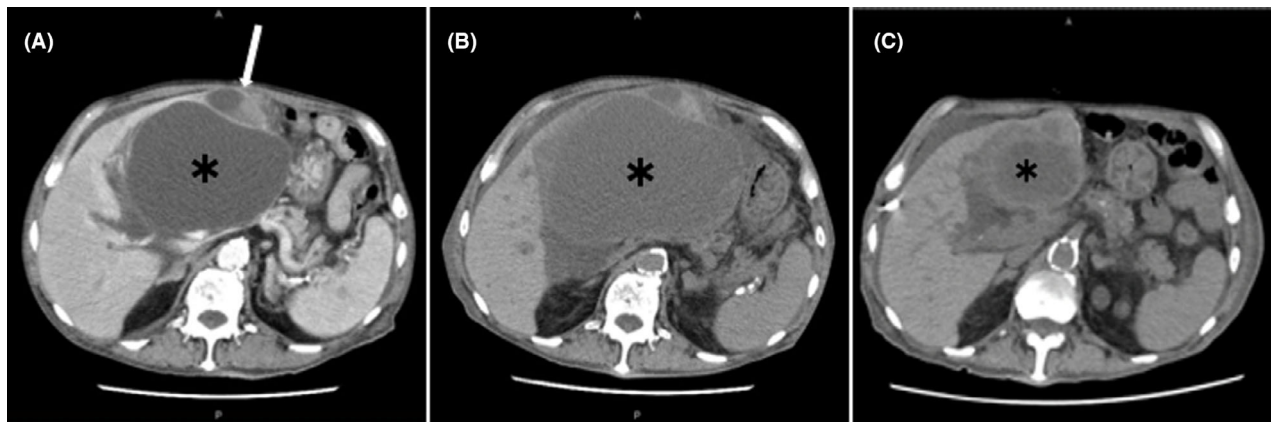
Time course of liver cysts on contrast-enhanced computed tomography until after the first percutaneous catheter drainage in an 84-year-old man. A, Contrast-enhanced computed tomography on admission. Small, infected cysts (white arrow) presenting with increased contrast enhancement of the wall and fat stranding around the cysts on the surface of the body. B, Seven days before the first percutaneous catheter drainage. Presence of the giant cyst is confirmed (asterisk). C, After the first percutaneous catheter drainage, the size of the giant cyst decreased (asterisk).
